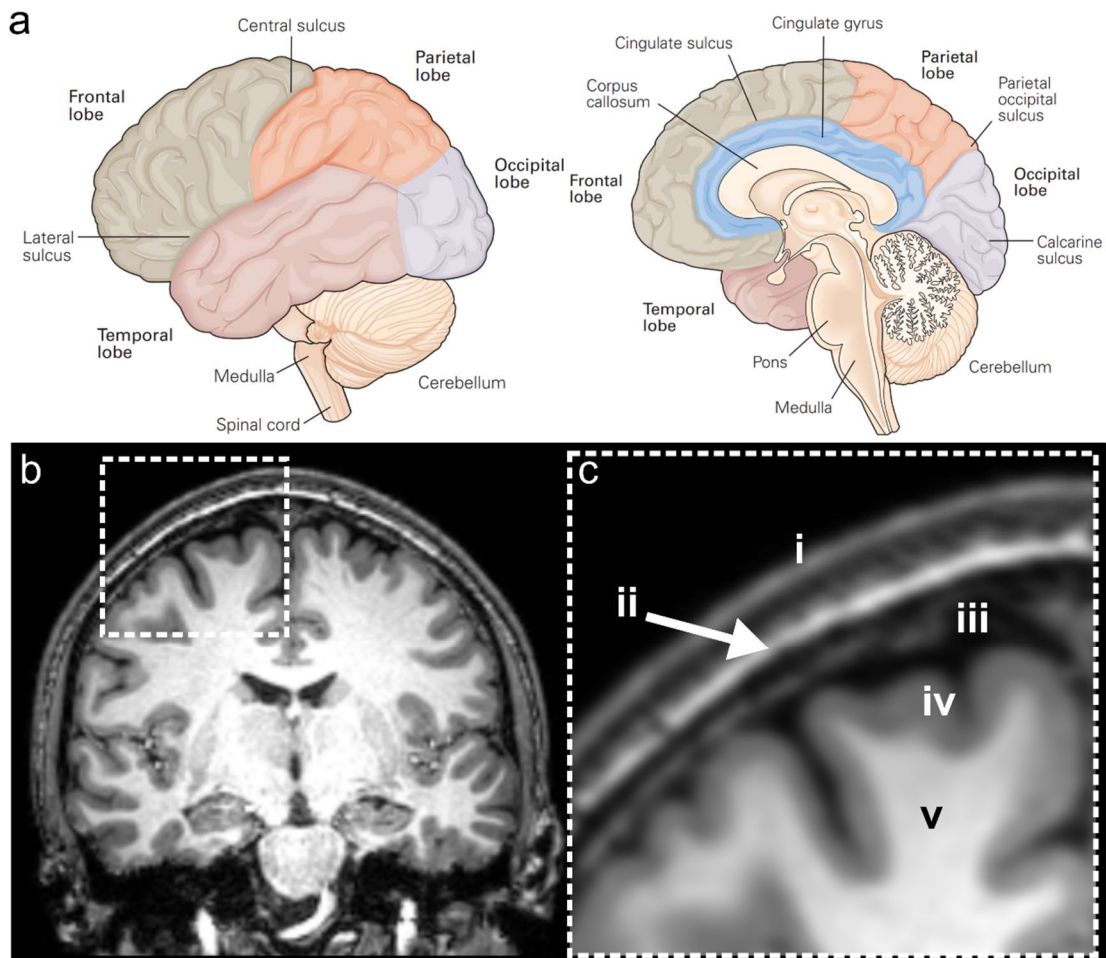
a) Macroscopic organisation of the brain showing the 4 main lobes (from (Schwartz J et al., 2012)). b) Coronal slice of a T1 weighted MRI with inset in c. c) MRI image showing the scalp (i), skull (ii), cerebrospinal fluid (iii), grey matter (iv), white matter (v).
